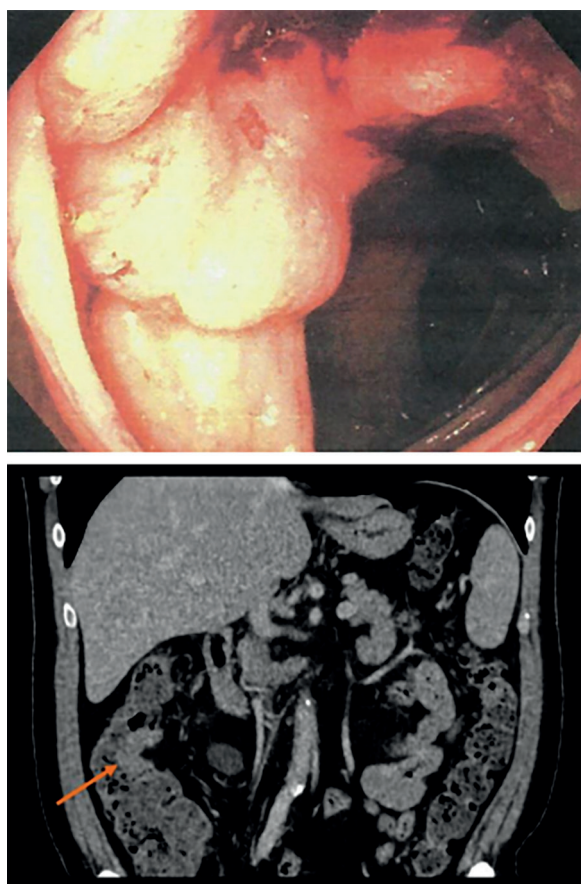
Images of the neoplasm at colonoscopy and CT.
